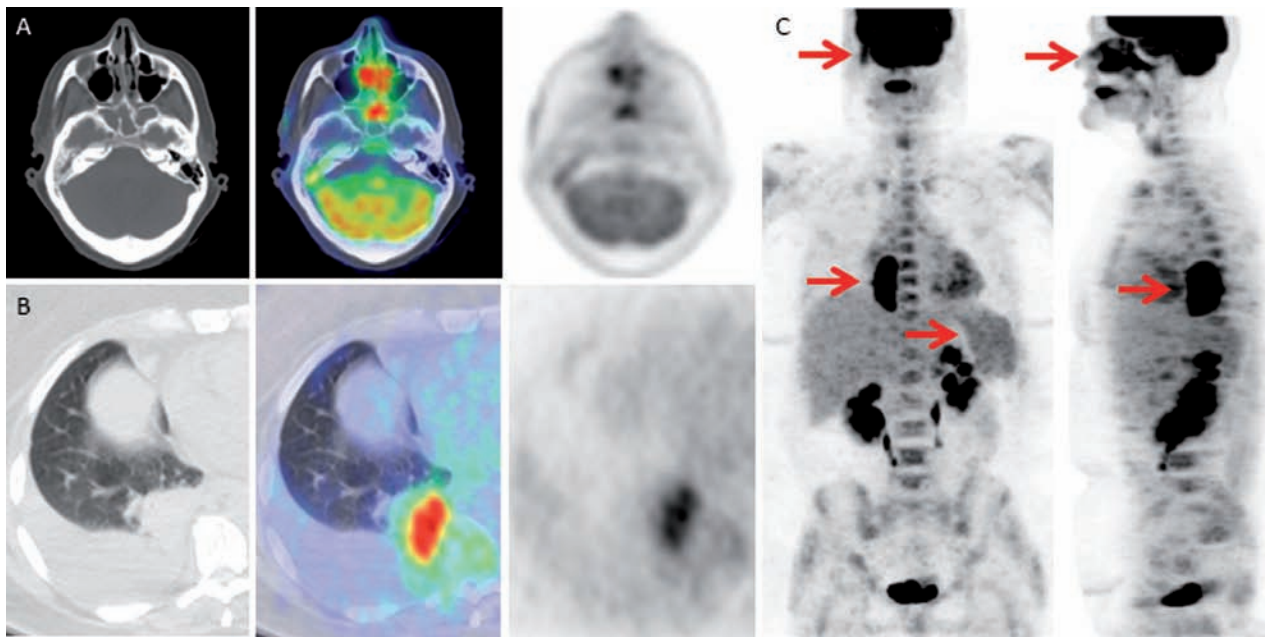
Multifocal Disease pattern on PET/CT suggests GPA. Patient no. 12 has a multifocal disease seen on PET/CT fits a pattern highly suggestive of GPA, including FDG avid lung and sinus disease. Intense FDG activity in the nasal mucosa and sphenoid sinuses with no clear underlying mass seen on axial PET/CT (A) and sagittal MIP PET image (C, arrow). Secondary obstructive non-FDG avid fluid in the sphenoid sinuses. The FDG activity in the nasal cavity and sinuses far exceeds that seen with more common etiologies of inflamed nasal and sinus mucosa, indicating this is not simple sinusitis. In addition, the right eustachian tube also had increased FDG activity likely due to GPA seen on frontal view of the MIP PET image (C, arrow) with non-FDG avid fluid in the right mastoid air cells (not shown). A right ear cholesteatoma was considered a possible diagnosis based on CT prior to the PET/CT. Intensely FDG avid solid sub-pleural lung mass with air bronchograms is seen on axial PET/CT (B) and MIP PET images (C, arrows) proved to be GPA. Adjacent non-FDG avid pleural effusion. Diffuse bone marrow and splenic FDG activity, which is seen in several cases of GPA at the time of initial diagnosis is seen on MIP PET images (C, arrow on spleen). The lung mass considered by itself on CT and PET/CT could easily be confused with malignancy. However, the pattern of activity in the lung and nasal passages should put GPA at the top of the differential. This patient had normal renal function, but the kidneys look similar on FDG PET/CT to those with GPA involvement seen in other patients on PET/CT, likely due to high urine background activity
